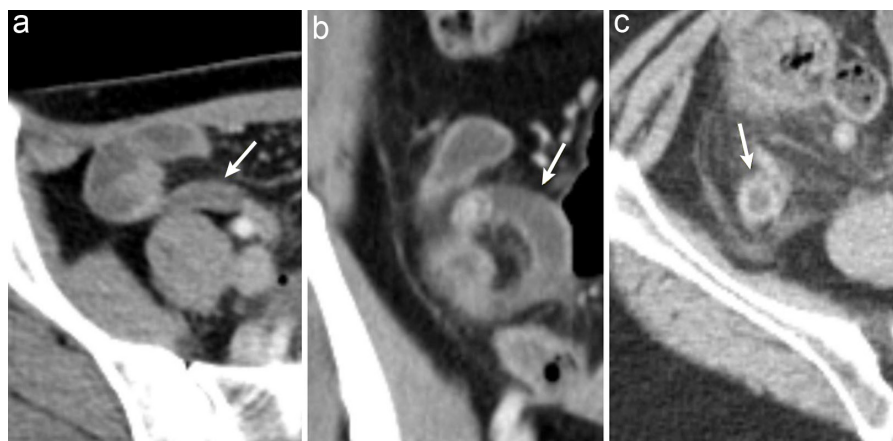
Example of the severity of periappendiceal fat stranding. On contrast-enhanced abdominal CT, the severity of periappendiceal fat stranding was graded as 0 (none) (a), 1 (mild) (b), and 2 (severe) (c).
